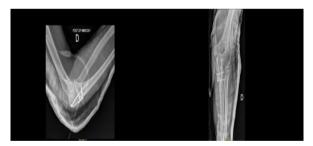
X-ray of the elbow, face and profile showing the presence of the fracture line on the olecranon.
